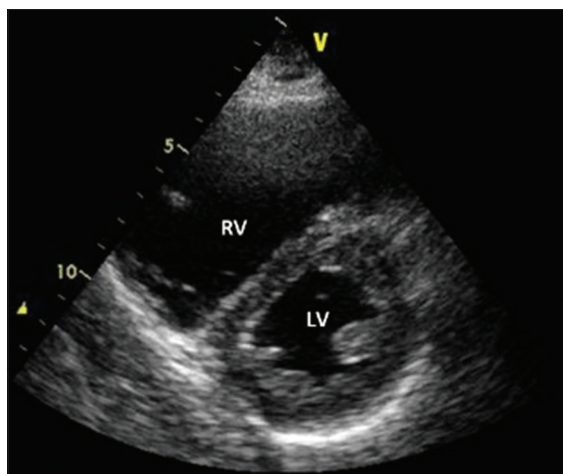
Echocardiography image of parasternal short axis demonstrating a dilated right ventricle and compression of the interventricular septum toward the left ventricle
